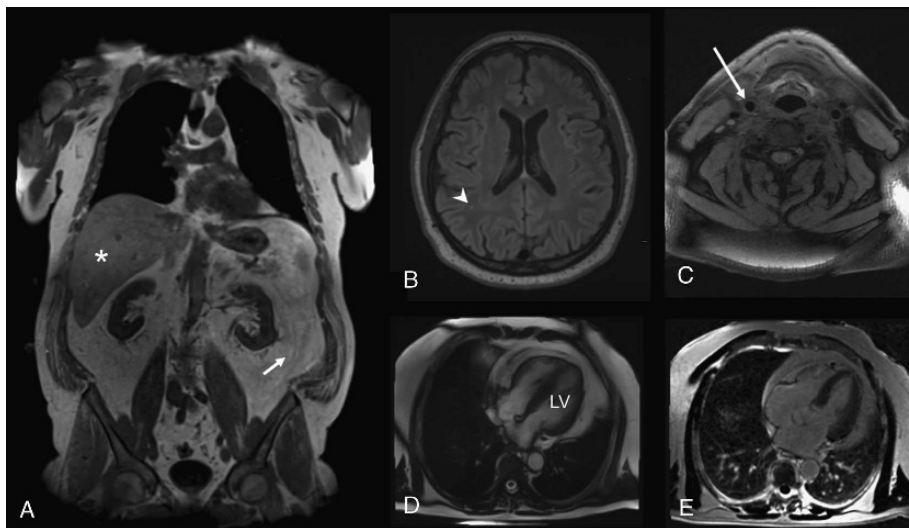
Imaging findings in a 61-year-old male as part of the study protocol. A, Two-point DIXON T1-weighted sequence for the assessment of visceral adipose tissue (VAT) volume from the femoral head to the cardiac apex (arrow) indicating high levels of VAT as well as hepatic proton density fat fraction (asterisk, measured on multi-echo VIBE T1-weighted sequences). B, Fluid-attenuated inversion recovery sequences demonstrating mild white matter lesions (arrowhead). C, Atherosclerotic carotid plaque was determined on black-blood T1-weighted fat suppressed sequences in the common carotid artery (arrow), the carotid bulb, and the proximal internal carotid artery. D, Cine-SSFP sequences were evaluated for the calculation of volume and mass left ventricle (LV). E, late gadolinium enhancement was detected on fast-low-single-shot inversion recovery sequences 4-chamber view. The overall MR phenotypic score in this subject totaled 4.
